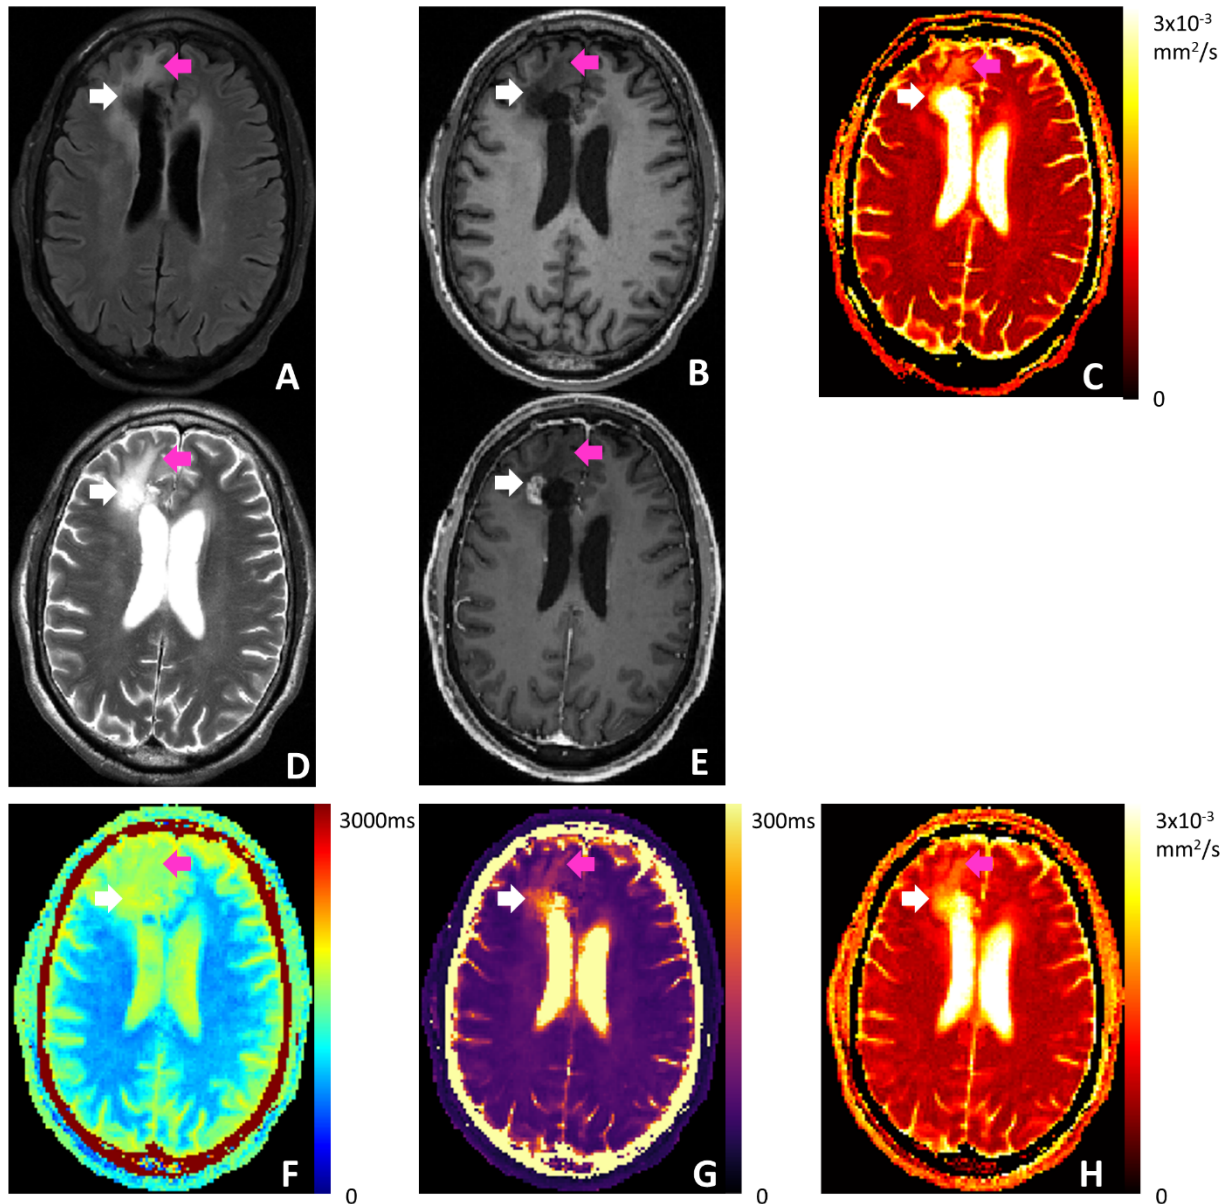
Clinical images and Multitasking T1/T2/ADC maps of a patient who was previously diagnosed with glioblastoma and underwent chemoradiation and surgery for tumor resection. (A) T2 FLAIR. (B) Pre-contrast T1 MPRAGE. (C) Clinical ADC map using RESOLVE. (D) T2 TSE. (E) Post-contrast T1 MPRAGE. (F-H) T1/T2/ADC maps obtained from Multitasking. White arrows point to the nodular enhancement area identified on post-contrast T1 MPRAGE. Purple arrows point to the surrounding edema. Multitasking T1/T2 maps reflect the tissue characteristics indicated by the clinical qualitative images. Multitasking ADC map is consistent with the clinical ADC map.
